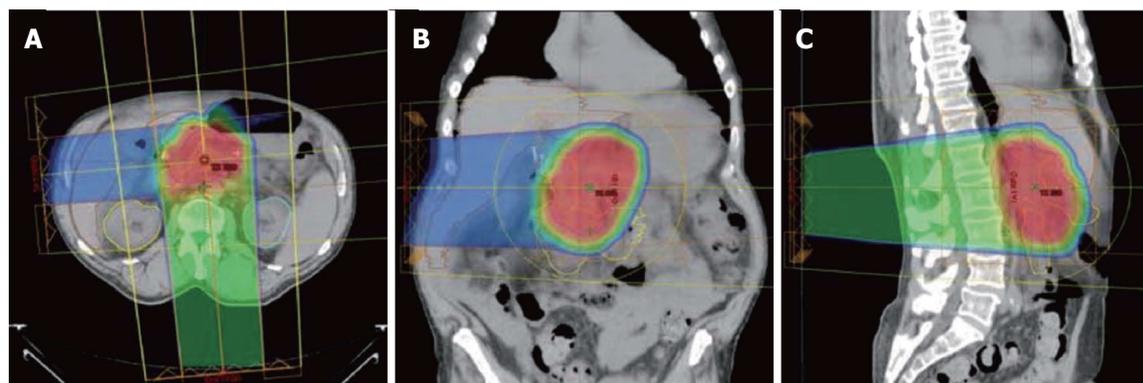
Typical proton dose distributions used to treat pancreatic cancers. Shown in the axial (A), coronal (B), and sagittal (C) projections. A heavily weighted (75% of the target dose) posterior or posterior oblique field is combined with a more lightly weighted (25% of the target dose) right lateral oblique field. Because protons are associated with a low entry dose and no exit dose compared with X-rays, there is significant sparing of small bowel and stomach tissue, which are highly sensitive to radiation damage. This normal-tissue sparing explains the low incidence of gastrointestinal toxicity when protons are used to deliver upper abdominal radiotherapy.
